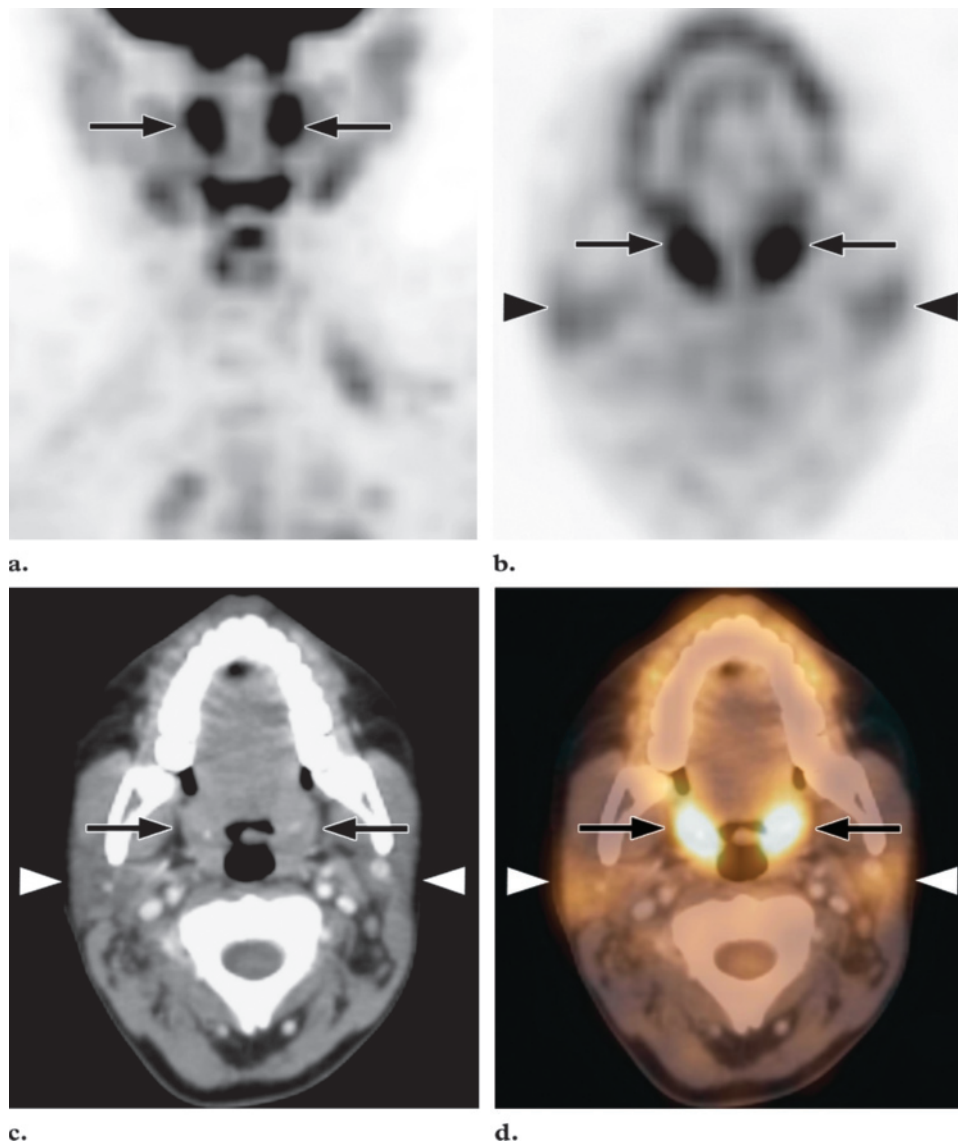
Maximum-intensity-projection (MIP) FDG PET image (a) and transverse FDG PET (b), CT (c), and fused PET/CT (d) images show marked and symmetric uptake in normal tonsils (arrows) as well as bilateral mild uptake in the parotid glands (arrowheads in b–d).
